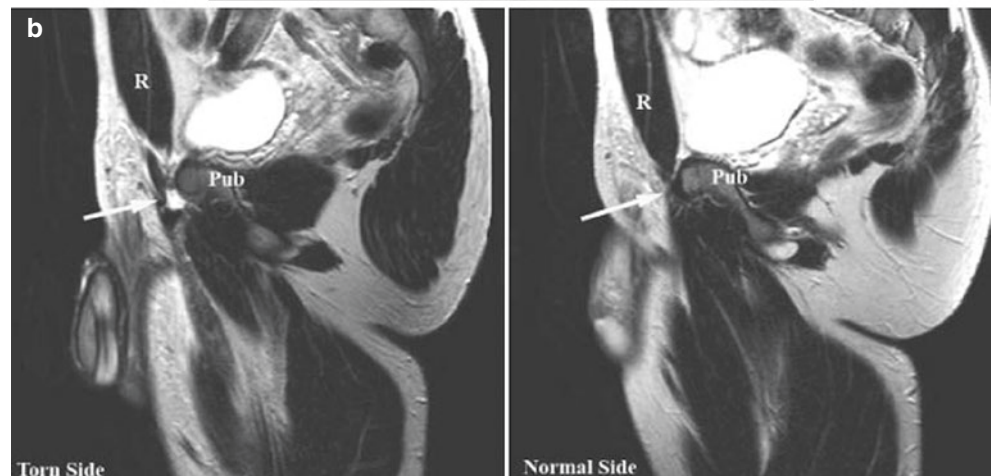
(a) T2 fat-suppressed MRI of right distal rectus tear (arrow pointing to bright fluid in cleft where rectus is torn); R = rectus, P = pubis. (b) Sagittal fat-suppressed sequence that shows distal rectus tear with discontinuity (left hand panel) and normal contralateral side (right hand panel). The arrow on the left panel points to the tear (appears bright on this sequence) and to the normal rectus insertion on the right panel. R = rectus, Pub = pubis
